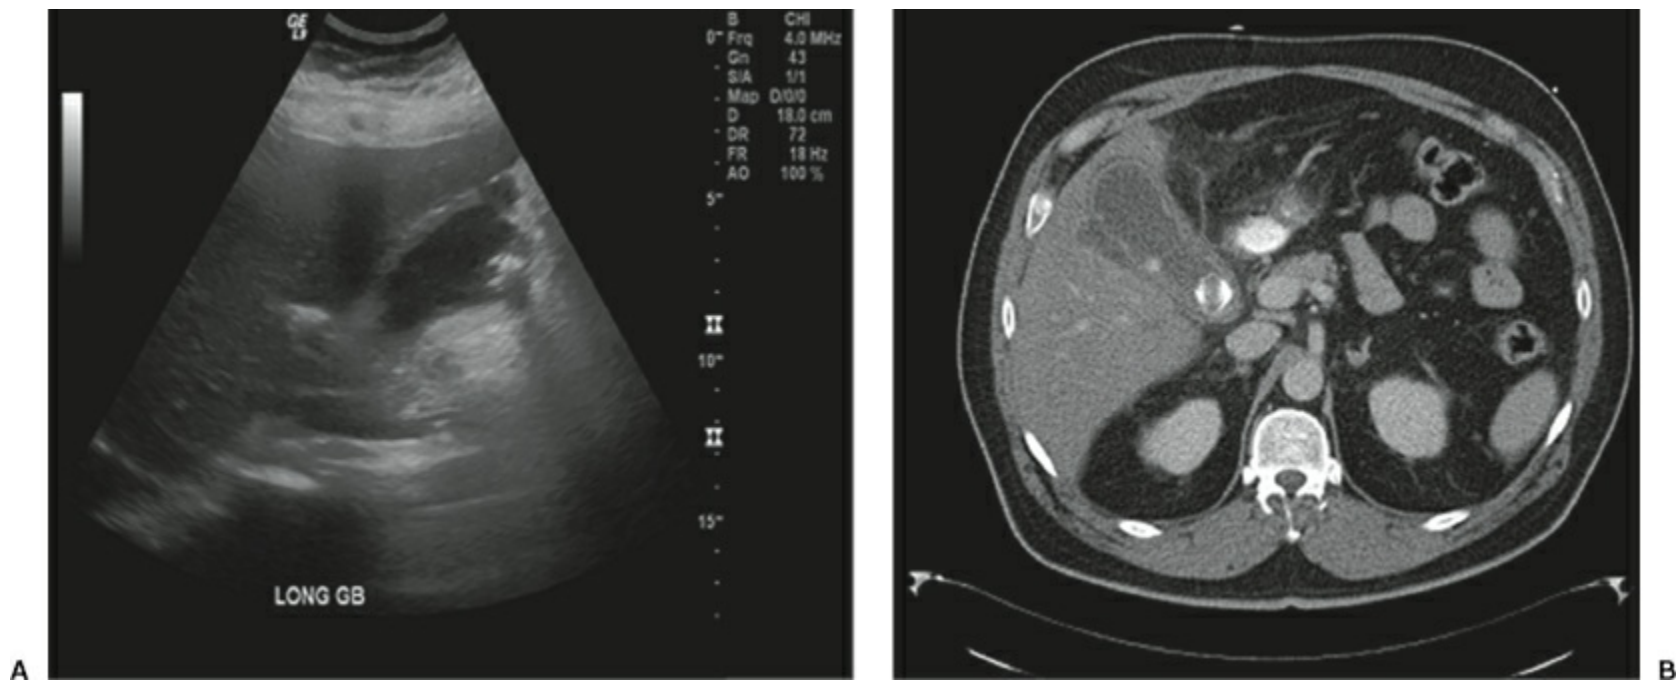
Examples from two patients with focal perforations of the gallbladder wall seen on US (A) and CT scan (B). Large perforations are visible with either modality, but CT is more sensitive for detecting smaller perforations. (Image courtesy of Aarti Sekhar, MD and David Schuster, MD, Emory University Department of Radiology.)
